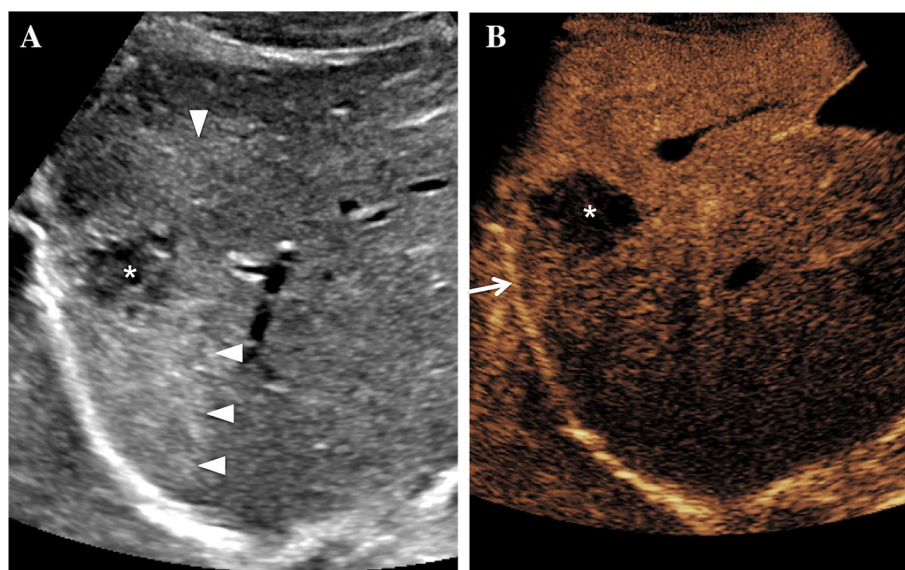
IV CEUS. Blunt abdominal trauma. 15-year-old boy sustained handlebar injury to the abdomen, presented with abdominal pain and mildly elevated liver enzymes. A Initial gray scale ultrasound of the abdomen revealed a heterogeneous subcapsular lesion in the subdiaphragmatic region of the right liver lobe (asterisk), surrounded by diffusely increased echogenicity (arrowheads). B Contrast-enhanced Ultrasound. Following intravenous injection of the ultrasound contrast agent, the lesion becomes very well demarcated due to lack of enhancement. The exact size of the lesion
